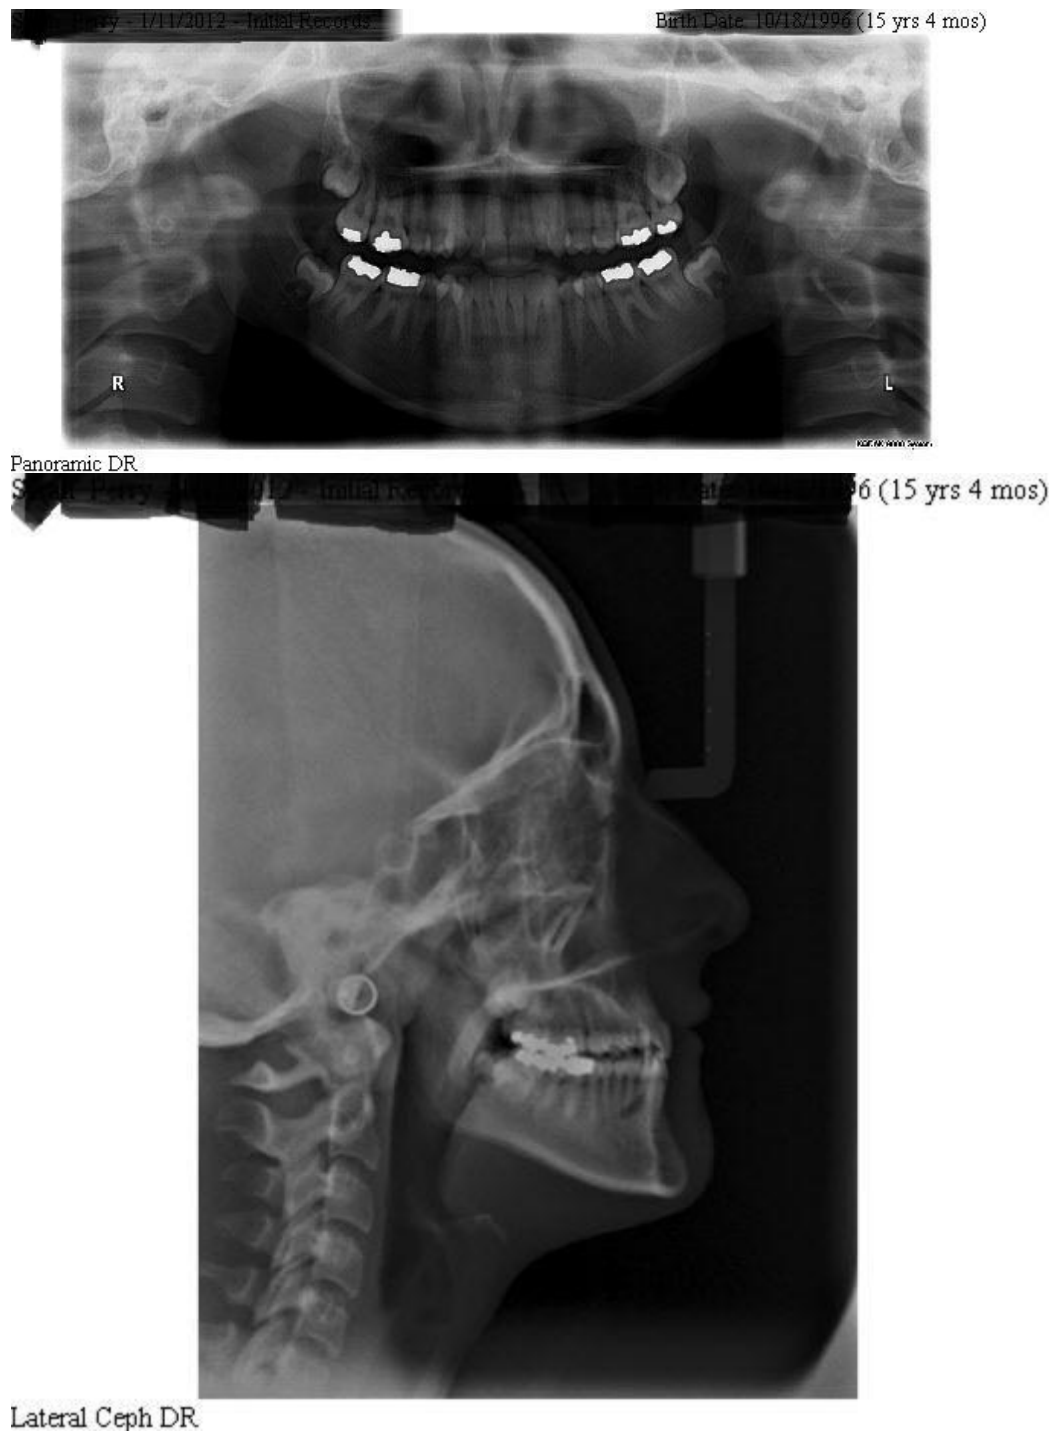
Above, panorex depicting cross-bite pathology, tooth appearance, and eruption status. Below, lateral ceph radiograph showing jaw alignment.
